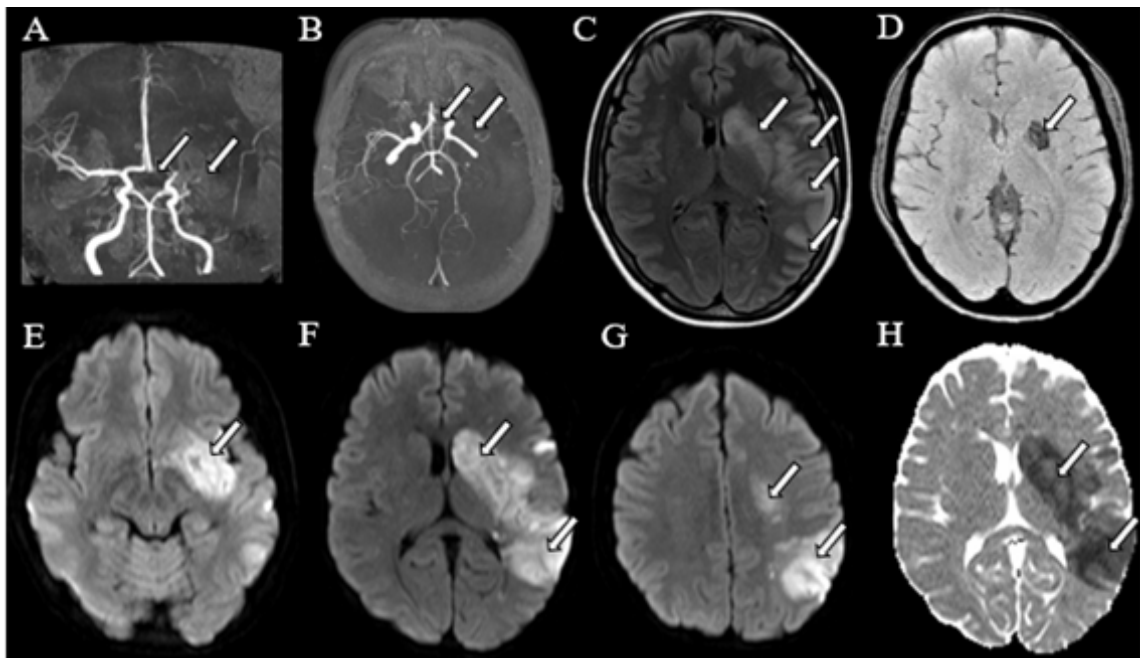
3D-TOF MRA (A, B) demonstrates occlusion at the left ICA bifurcation extending to the MCA and ACA stems; FLAIR image (C) shows hyperintensity in left MCA territory, including basal ganglia; SWI (D) hypointensity in left basal ganglia indicating hemorrhagic foci; DWI (E, F, G) and ADC-map demonstrate markedly restricted diffusion, indicating subacute stroke.
